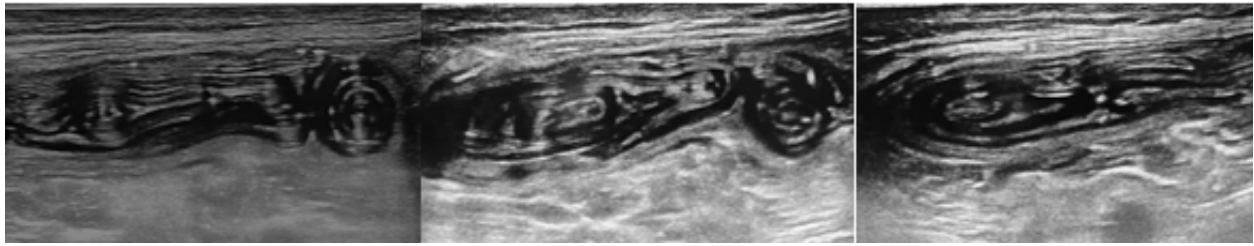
Ultrasound images with high frequency probe (11 - 16 MHz), showing intramuscular cysts, containing serpiginous hydatid membranes.
